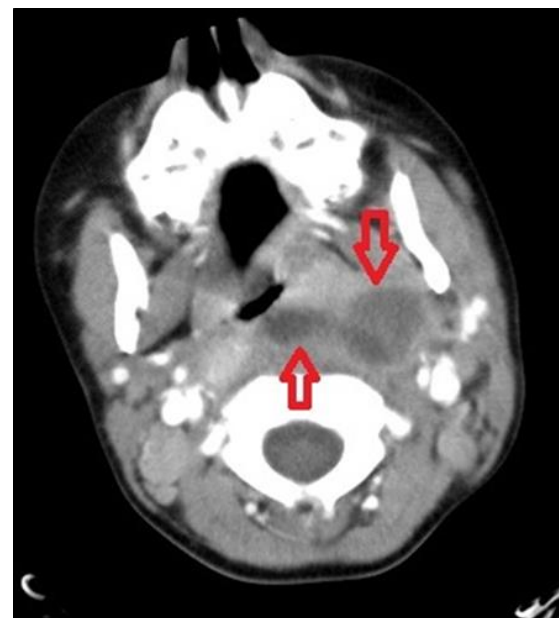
Parapharyngeal space abscesses in the axial CT scan with intravenous contrast
